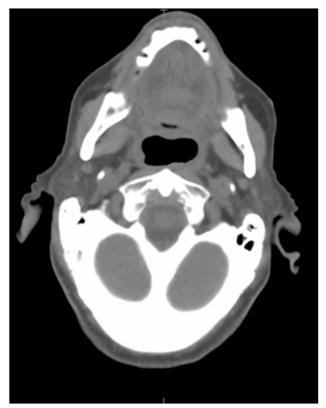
Axial computed tomography showing radiologic remission in the pharynx.
